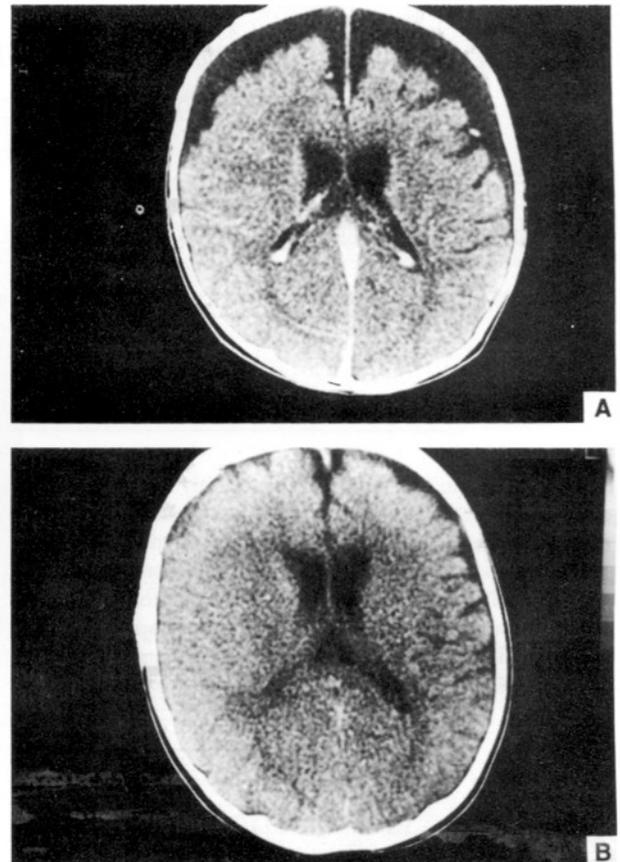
(a) CT of a 6-month old by showing bilateral subdural collection, (b) note the resolution of subdural collection 2 months after S-P shunting.
